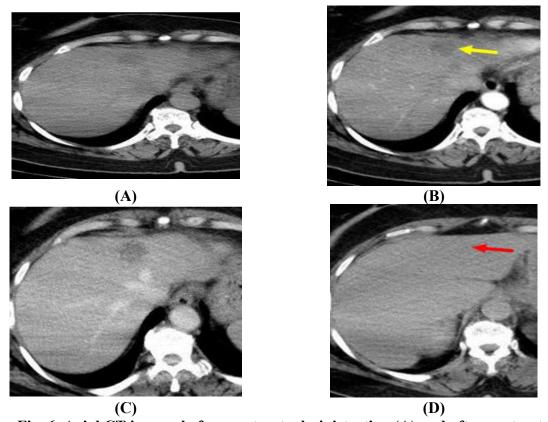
Axial CT images before contrast administration (A) and after contrast administration at arterial phase (B) Porto Venous phase (C) and delayed phase (D) show left hepatic lobe focal segment IV A measure 20 mm show peripheral arterial nodular enhancement(B) (yellow arrow) with iso dense at delayed phase (D) (red arrow)
